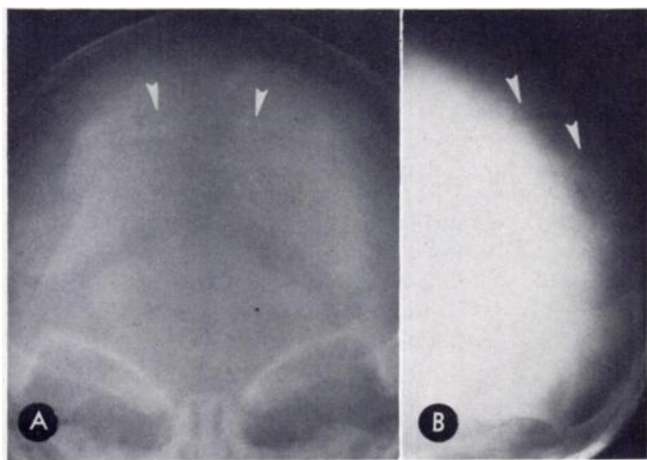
Frontal (A) and lateral (B) roentgenograms of skull of newborn infant with linear defect in posterosuperior aspect of each parietal bone presumably caused by parietal fissure or incisura (arrows).
